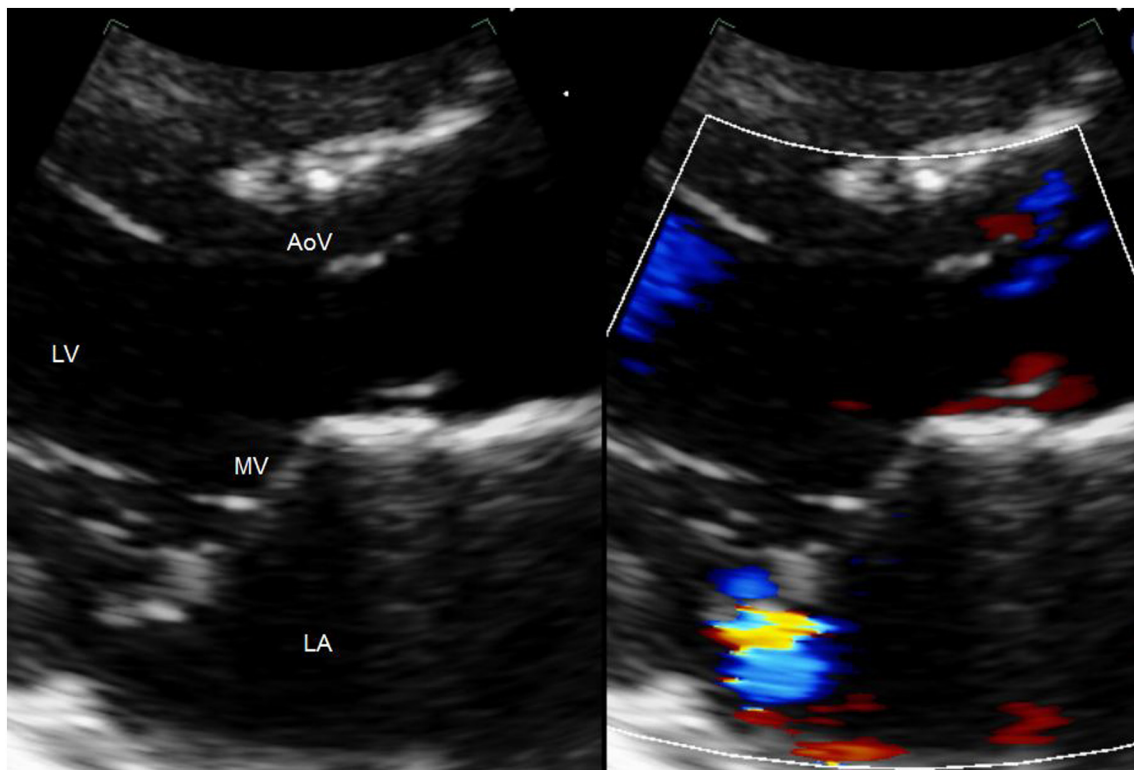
Parasternal long axis view showing a thickened and redundant mitral valve prolapsing into the left atrium during systole with posteriorly directed trivial mitral regurgitation.
